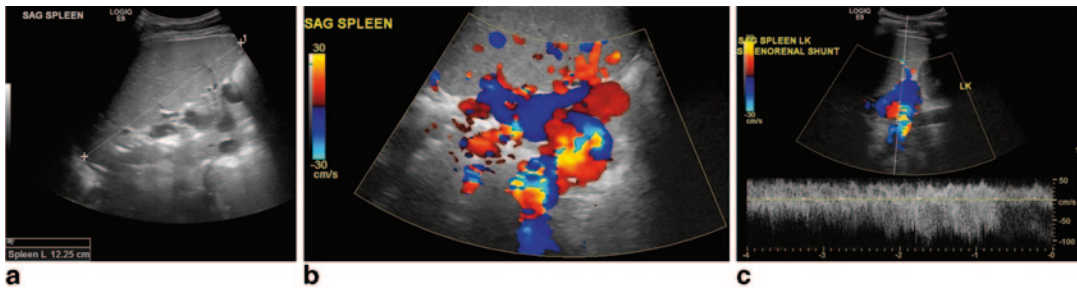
Splenorenal shunt. a Ultrasound identifies the dilated vessels at the splenic hilum and documents the splenomegaly. b Hepatopetal flow identified in the splenic
